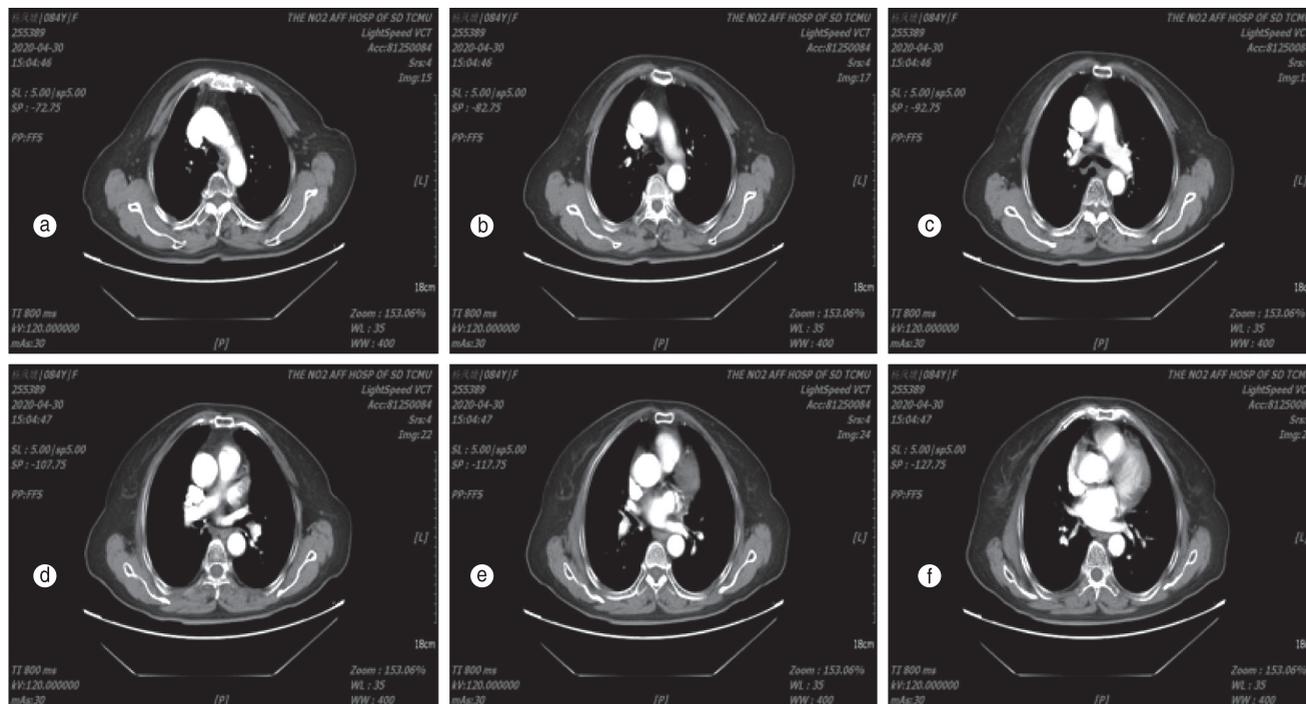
After 4 cycles of treatment, the reexamination of CT on April 30, 2020 shown: esophageal tumor continued to shrink, and normal swallowing showed no uncomfortable symptoms, and the condition was stable
